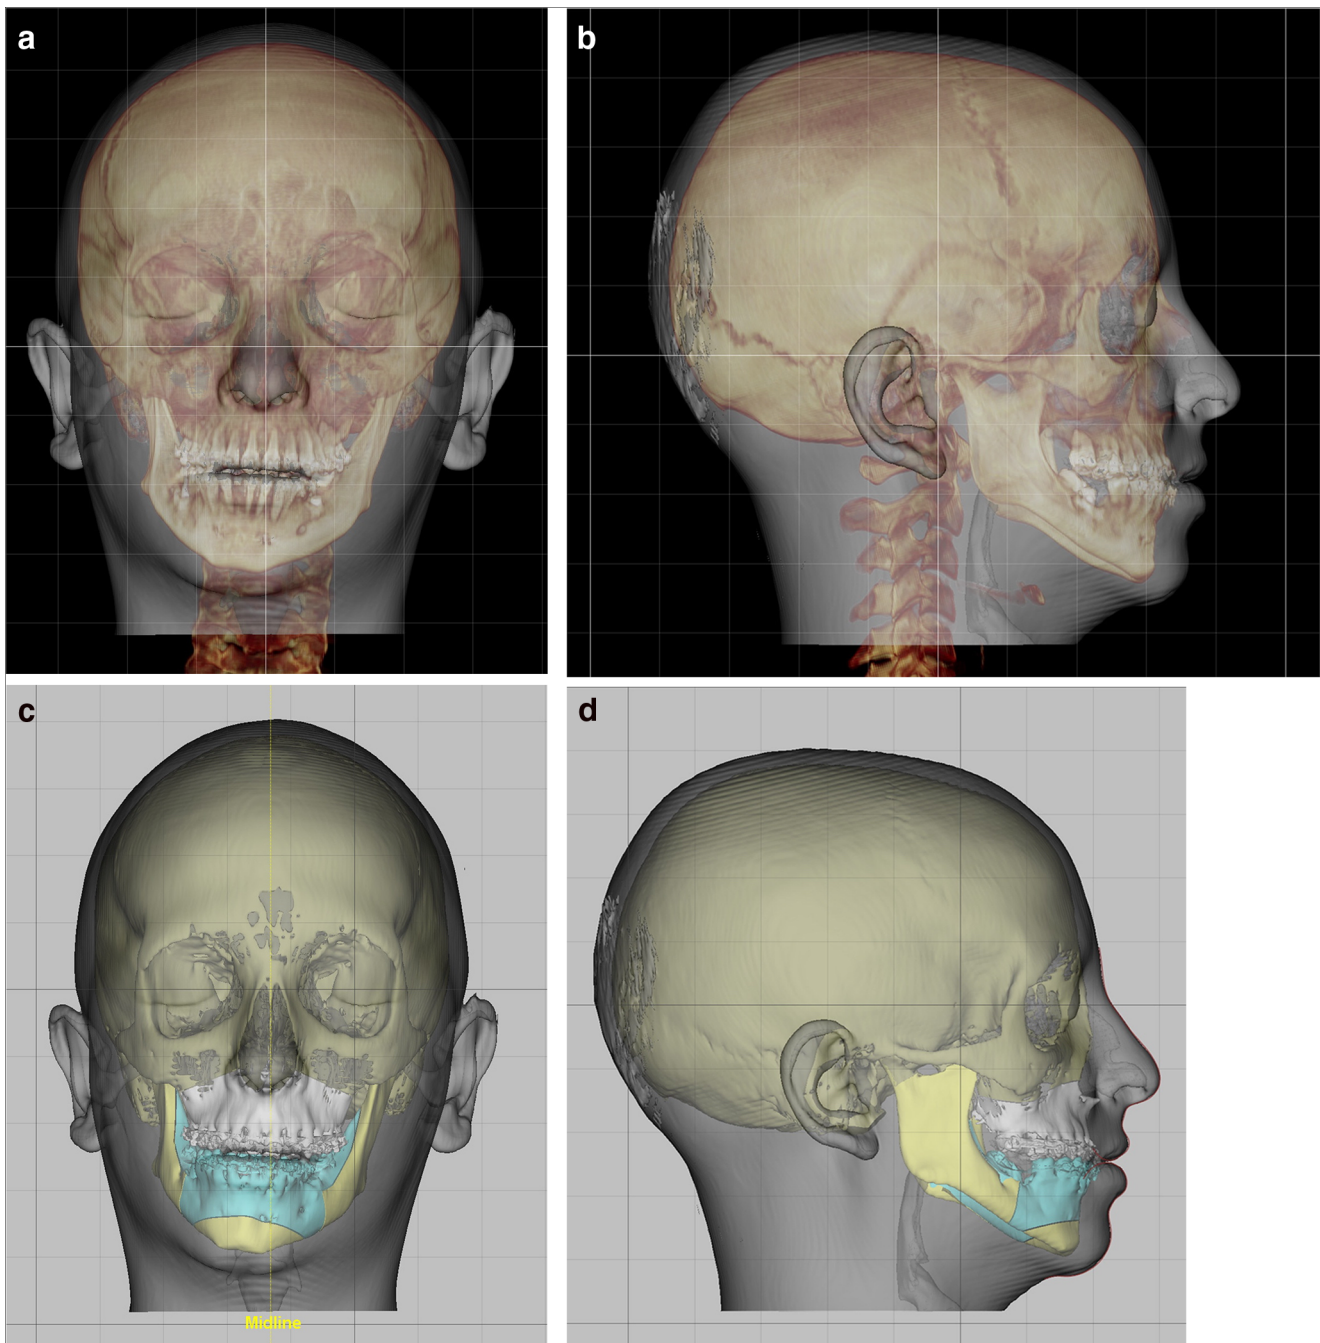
Establishing NHP (a frontal view; b lateral view) and virtual patient generation in NHP and CR after digital dental models superposition onto 3D CT reconstruction (c frontal view; d lateral view)
